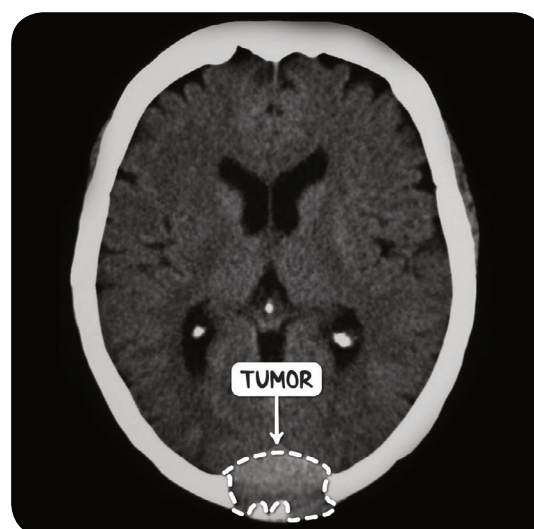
A CT scan of the head in the axial plane demonstrating a myeloid sarcoma, or chloroma, of the occiput. The tumor is extradural and destroying the overlying bone.
